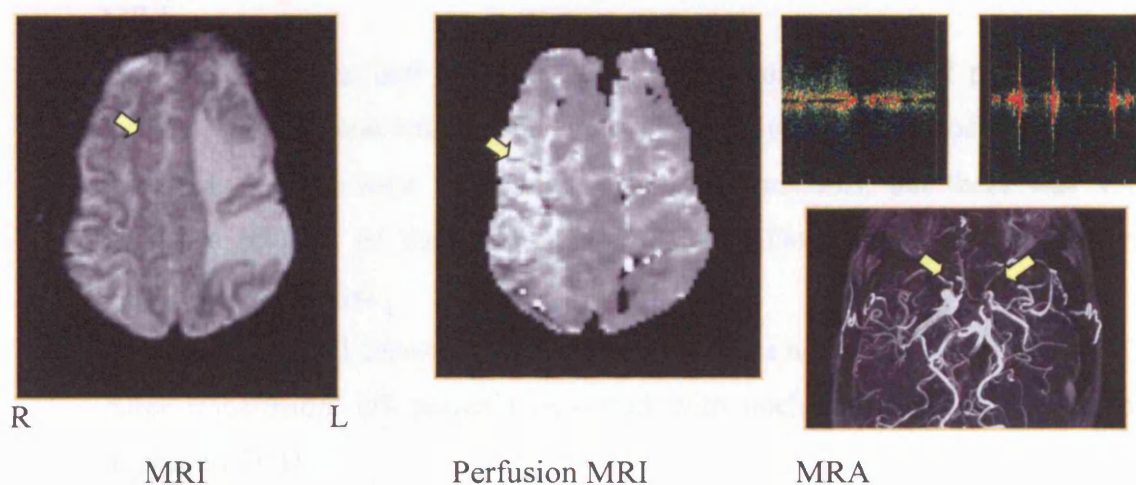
Long-term blood transfusion, after 2 years (the patient stopped blood transfusion a year before due to erythrocyte antibody formation). T2-w MRI. Bilateral infarctions, patchy white matter ischaemic lesions, bilateral basal ganglia infarcts & generalised atrophy. Impaired Perfusion MRI. Increased mean transit time of the passage of IV contrast bolus in the MCA territories bilaterally (cortical and subcortical regions) with impaired cerebral perfusion on the cerebral perfusion on the right MCA region. : MRA. Both proximal MCAs and left terminal ICA are narrowed, moyamoya collaterals. Transcranial Doppler ultrasound (TCD): decreased MCA blood flow velocities bilaterally.
